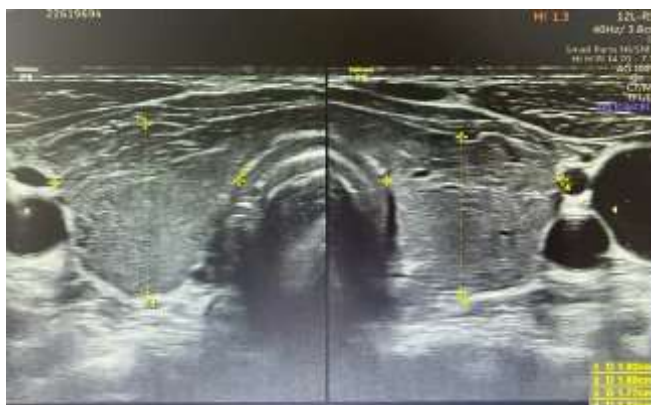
Thyroid Ultrasound: 2-lobed parenchyma thyroid is hypoechoic at the level of neck muscles, hypervascularity on Doppler ultrasonography
